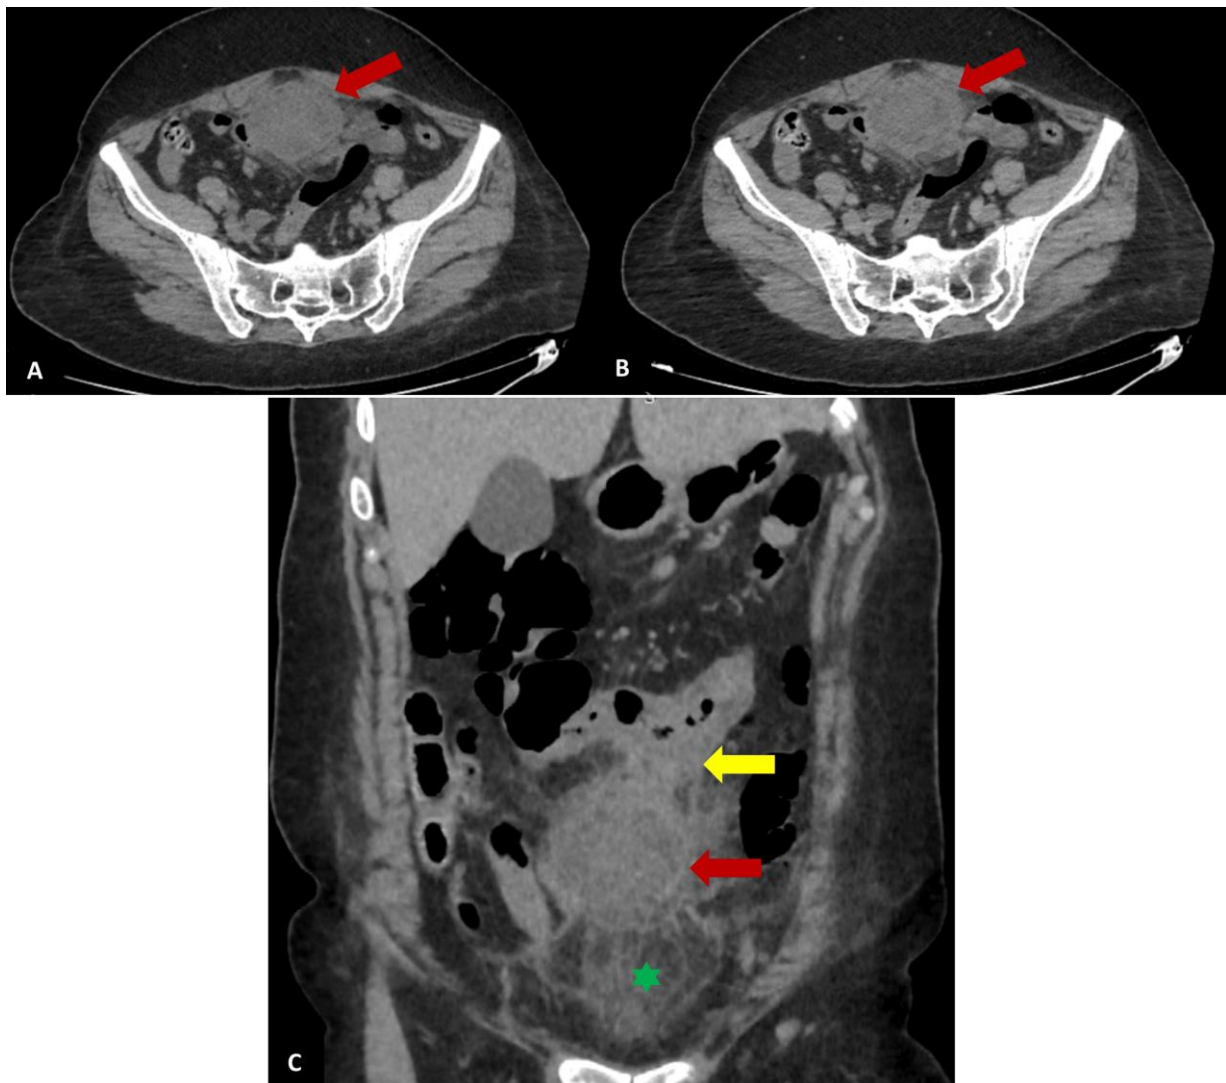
Abdominopelvic CT scan without (A) and with contrast enhancement (B, C) showing an intra-abdominal collection (red arrow), with surrounding fat stranding (asterisk), in contact with a thickened transverse colon wall (yellow arrow), consistent with an abscess complicating epiploic appendagitis
